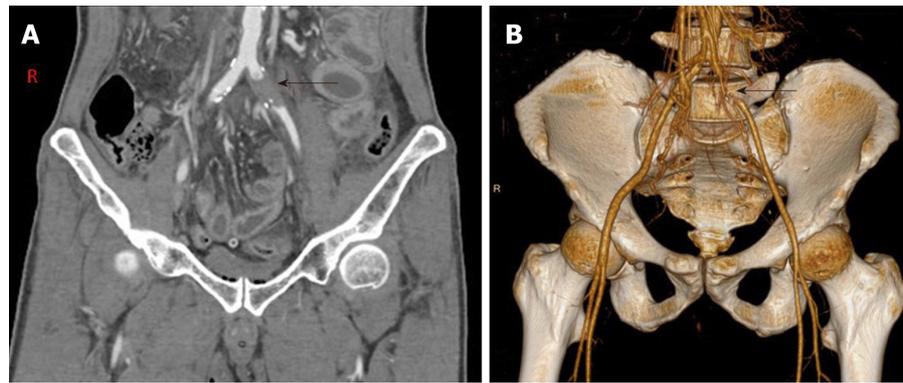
Abdominal computed tomography findings of a common iliac artery occlusion. A: Abdominal computed tomography angiography confirmed a 2.5 cm occlusion of the left common iliac artery, with preservation of the common iliac bifurcation and distal arterial tree. There was no evidence of active arterial bleeding or pseudoaneurysm formation (arrow); B: Three-dimensional computed tomography angiogram reconstruction showed obvious occlusion of the left common iliac artery (arrow).
